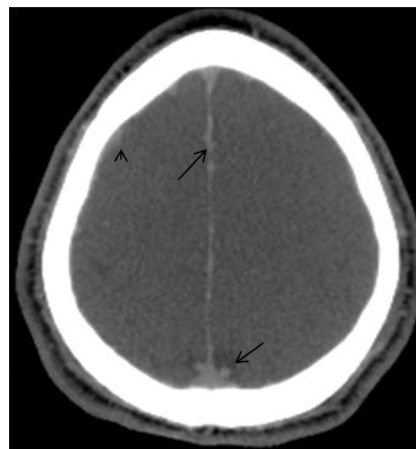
The "lumpy" falx. Axial noncontrast CT image demonstrates irregularity along the falx (arrows). This is related to high attenuation within the venous structures and not subarachnoid hemorrhage. More peripherally located venous structures also demonstrate high attenuation (arrowhead).
